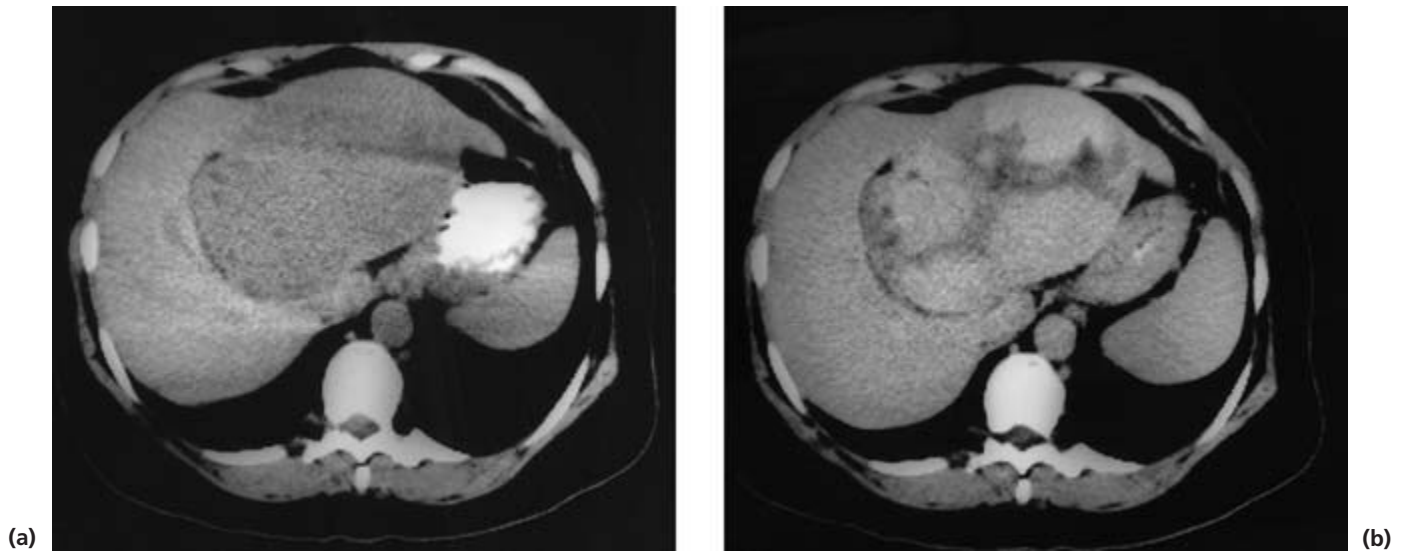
(a) An unenhanced CT scan showing a large, low attenuation lesion in the left lobe of the liver. (b) Following enhancement, dynamic scanning shows gradual infilling of the lesion which eventually became isodense with the remainder of the liver. These are the characteristic appearances of a cavernous haemangioma.
